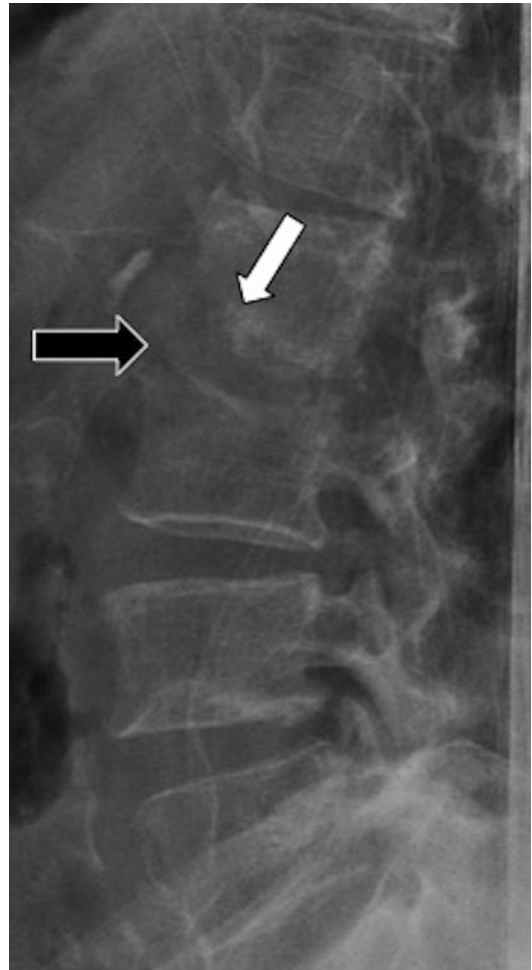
Lateral radiograph of the lumbar spine demonstrates early disc height loss at L2–L3 (black arrow) in combination with ill-defined endplate erosions (white arrow), findings in keeping with discitis
